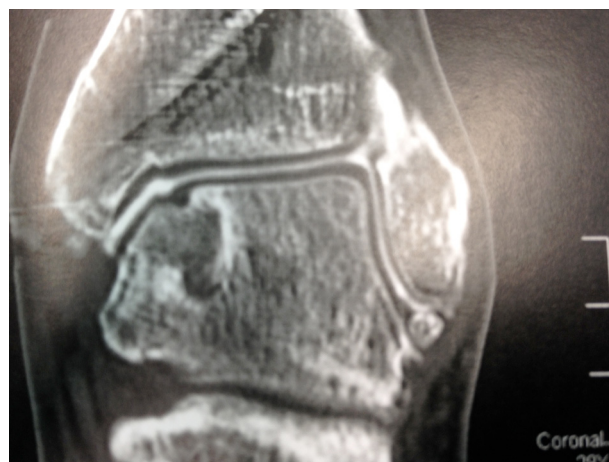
Computed tomography arthrography 12 months after surgery showing perfect incorporation of the graft with restoration of a smooth cartilage surface.
